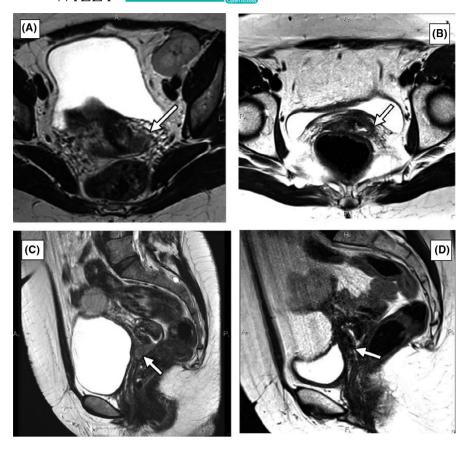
Post-treatment MRI shows complete tumor response when compared with the baseline study. Axial (A, B) T2-weighted MR images show IIB stage primary cervical tumor with parametrial invasion before treatment (arrow A) and no parametrial extension 3 mo after radiotherapy (arrow B). Sagittal (C, D) T2-weighted MR images show cervix tumor prior to (arrow C) and after (arrow D) the treatment—cervix is contracted with no evidence of disease 3 mo after the finish of radiotherapy
